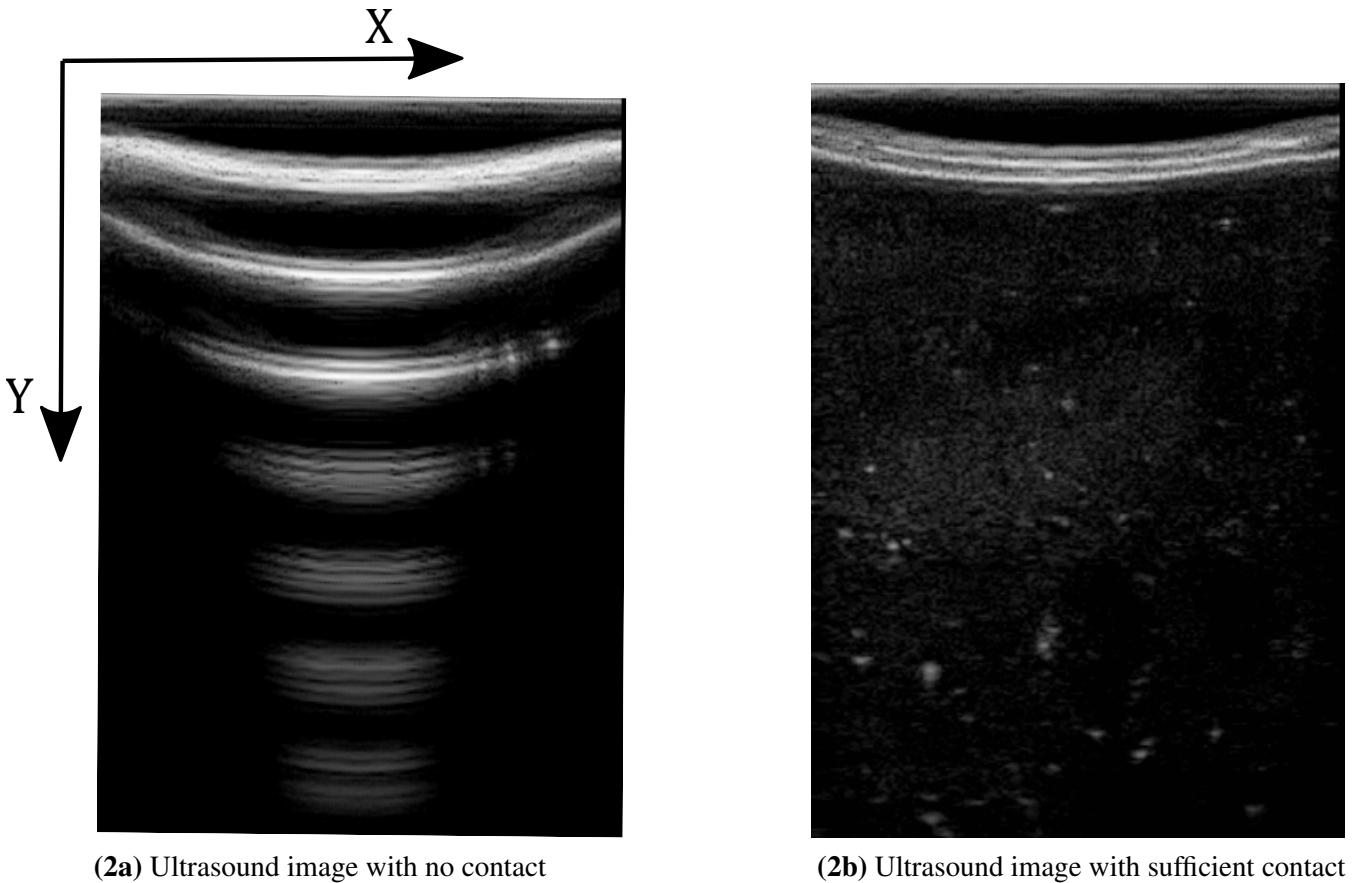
Ultrasound images with and without contact between tissue and probe
